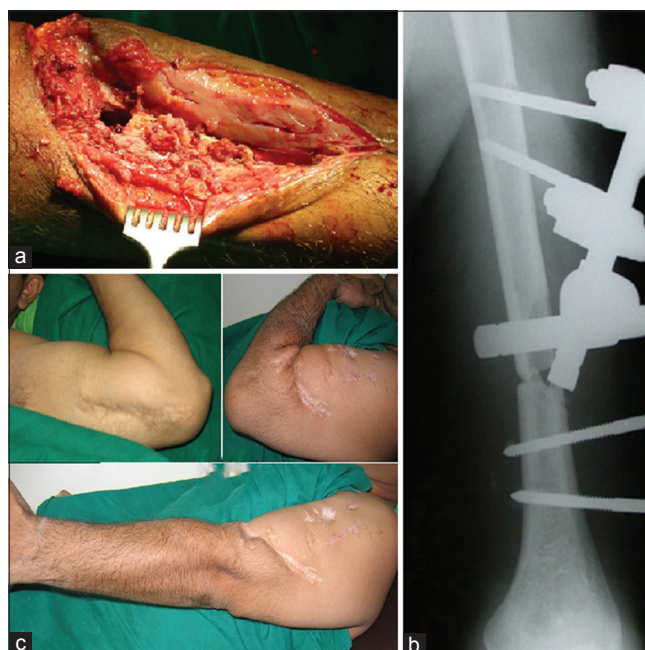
(Case A1) (a) Peroperative photograph showing, open wound, extensive contamination of open fracture wound taken up for debridement. (b) Radiograph of humerus anteroposterior view showing external fixator *in situ* (c) Clinical photograph showing final range of motion
